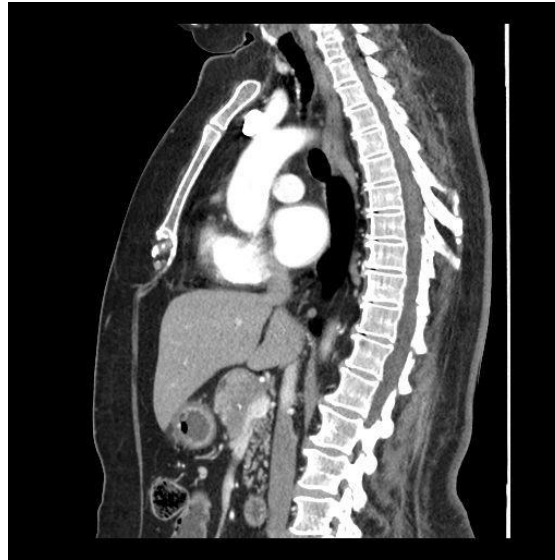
First follow-up sagittal plan abdominal CT scan image. It reveals partial response with decreased tumoral mass size, still presenting vascular compromise.
